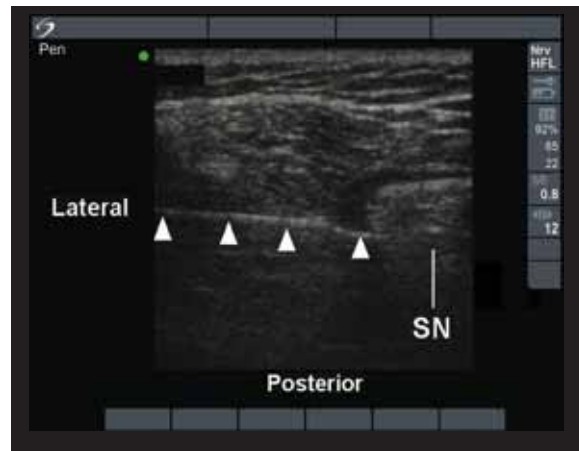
Ultrasound image of the supine popliteal approach to the sciatic nerve.
